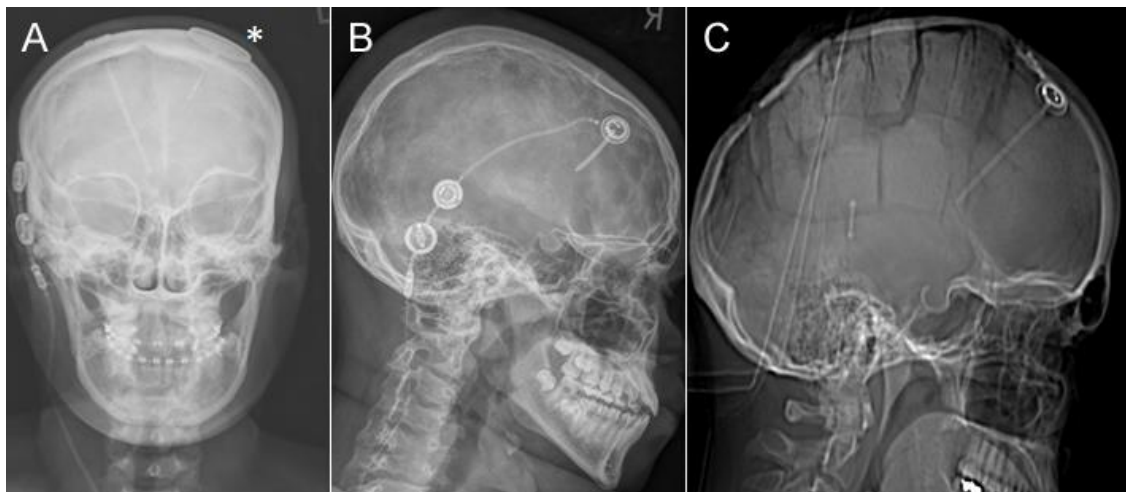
X-ray representation of tICPM devices.
